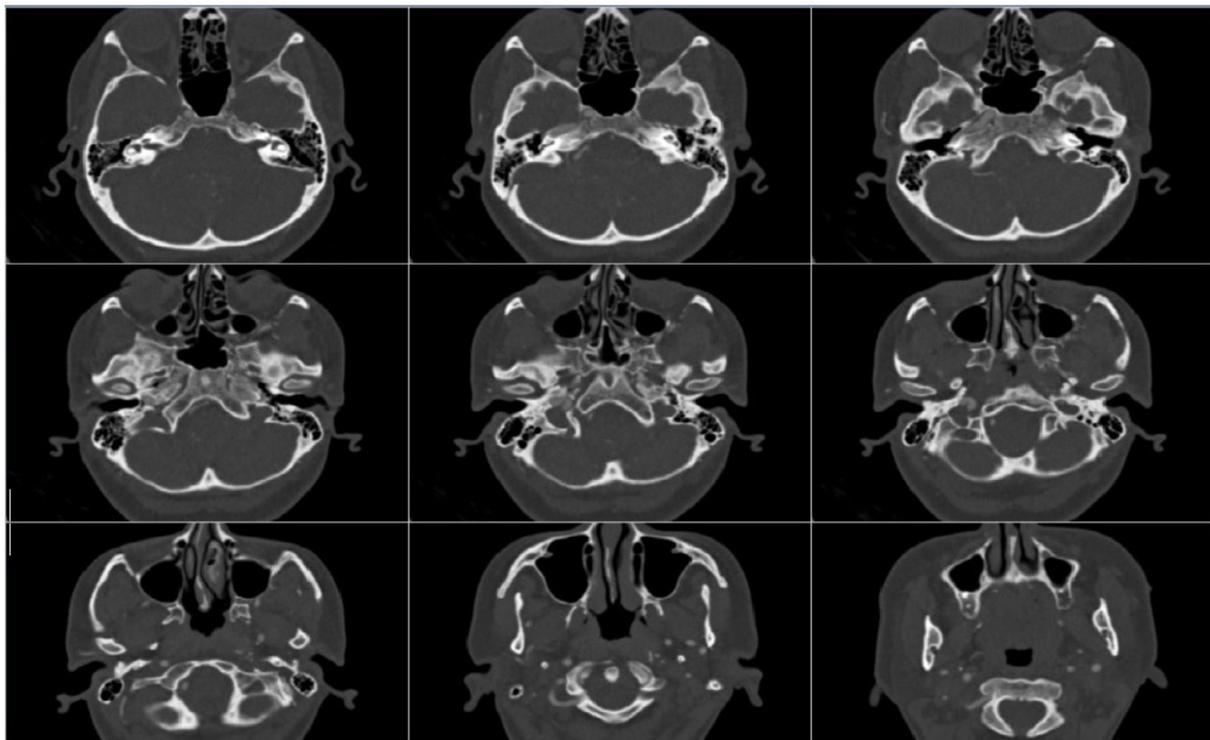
Cranial CT showed that the left carotid canal was hypoplastic.
